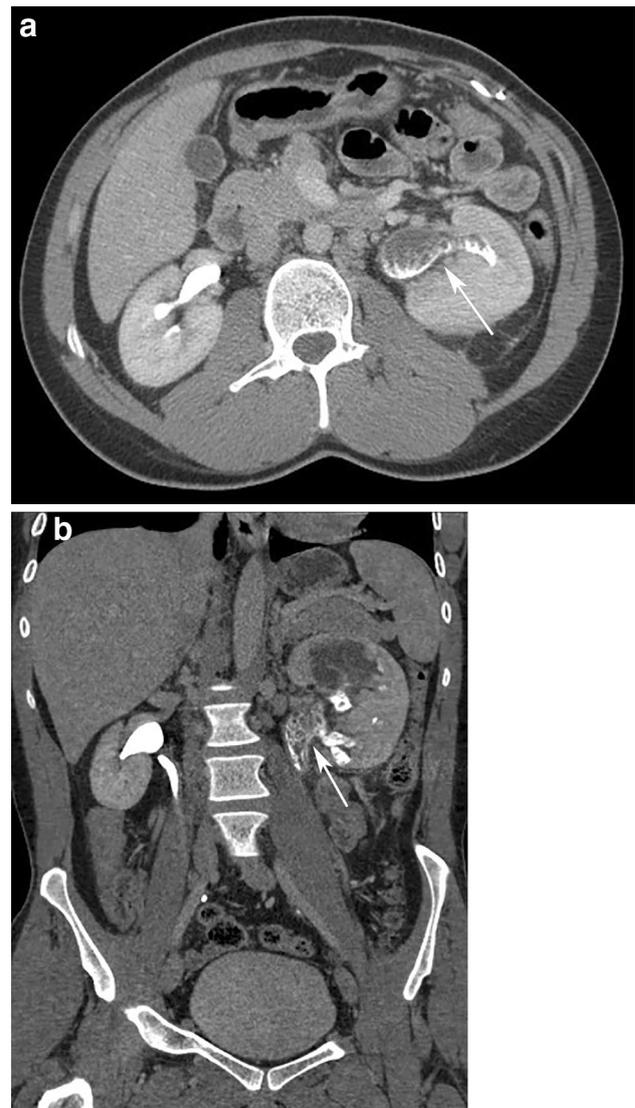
Keratinizing desquamative squamous metaplasia. a An axial excretory phase contrast-enhanced CT image through the abdomen demonstrates multiple linear filling defects distorting the dependently layering excreted contrast material in a mid left renal infundibulum and in the left renal pelvis (arrow). b A coronal reformatted image demonstrates a large number of linear and ovoid filling defects occupying the nearly all of the left renal collecting system (arrow). The process extends into the upper pole of the left kidney
